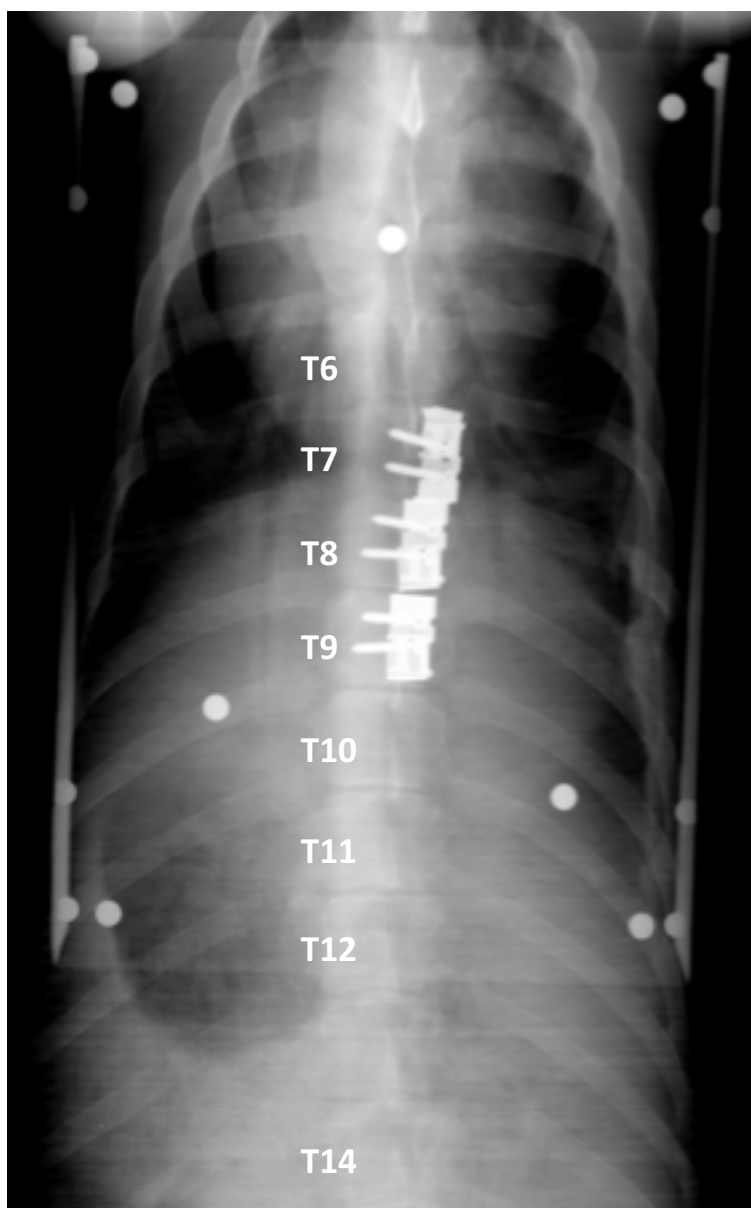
Postoperative postero-anterior radiograph showing implant positioning.
